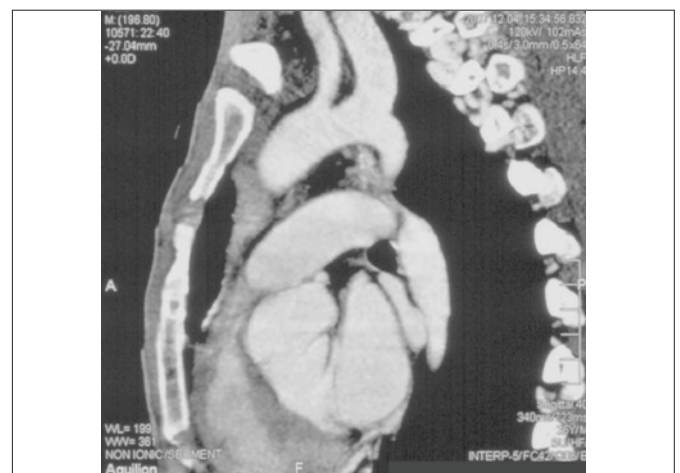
CT scan showing the atretic aortic isthmus.
